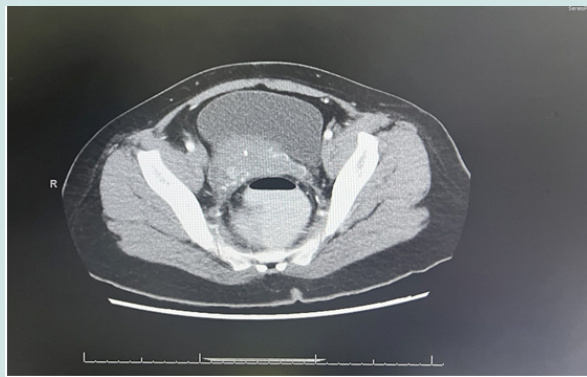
A CT scan of the abdomen and pelvis, performed with and without contrast, showing an area of concentric narrowing in the rectosigmoid. The narrowed area has a craniocaudal length of 5 cm and a maximum thickness of 2 cm, with the distal end situated approximately 18 cm from the anal verge. No extra-serosal invasion or locoregional lymph nodes are visible.
